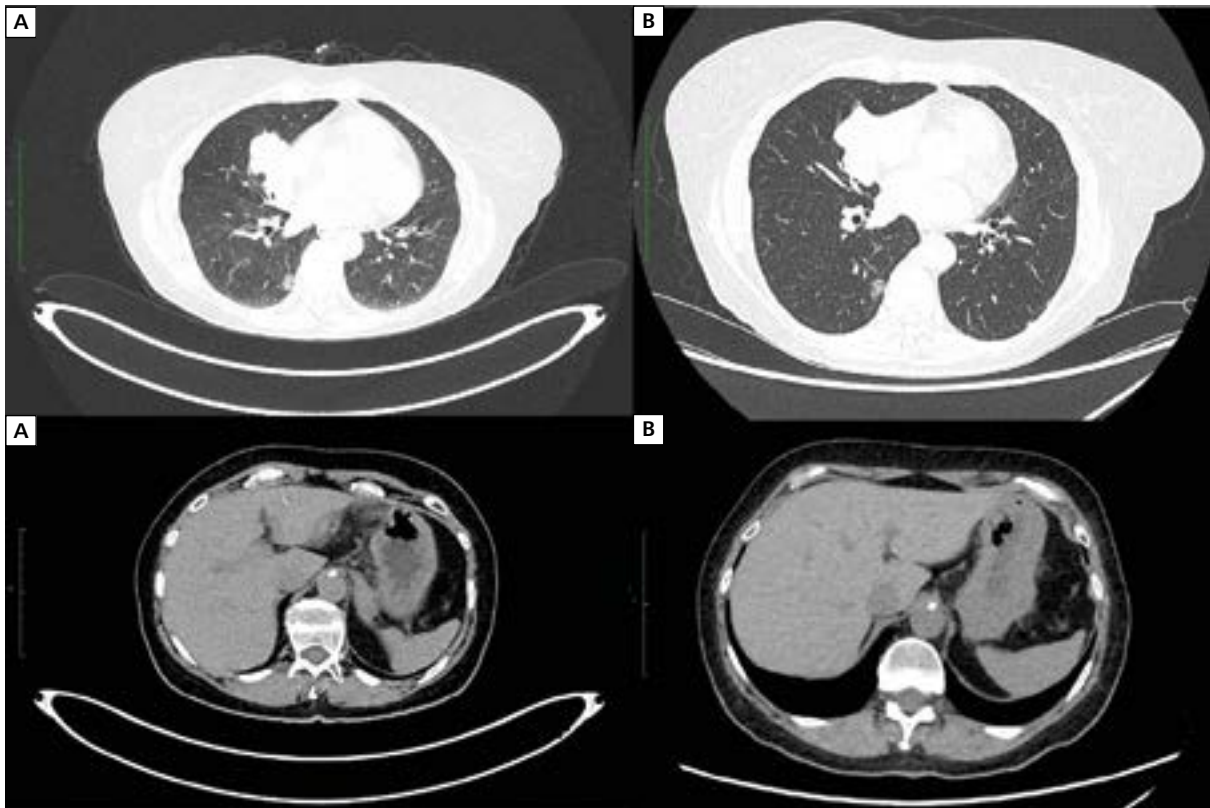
Computed tomography (CT) scan images; A. An irregular nodal-infiltrative conglomerate in the right pulmonary hilum; B. Partial response of the infiltrative-nodal lesion in the left lung hilum during immunotherapy; C. An infiltration between the left adrenal gland and the stomach; D. Complete remission of the infiltrative lesion in the abdominal cavity during immunotherapy
